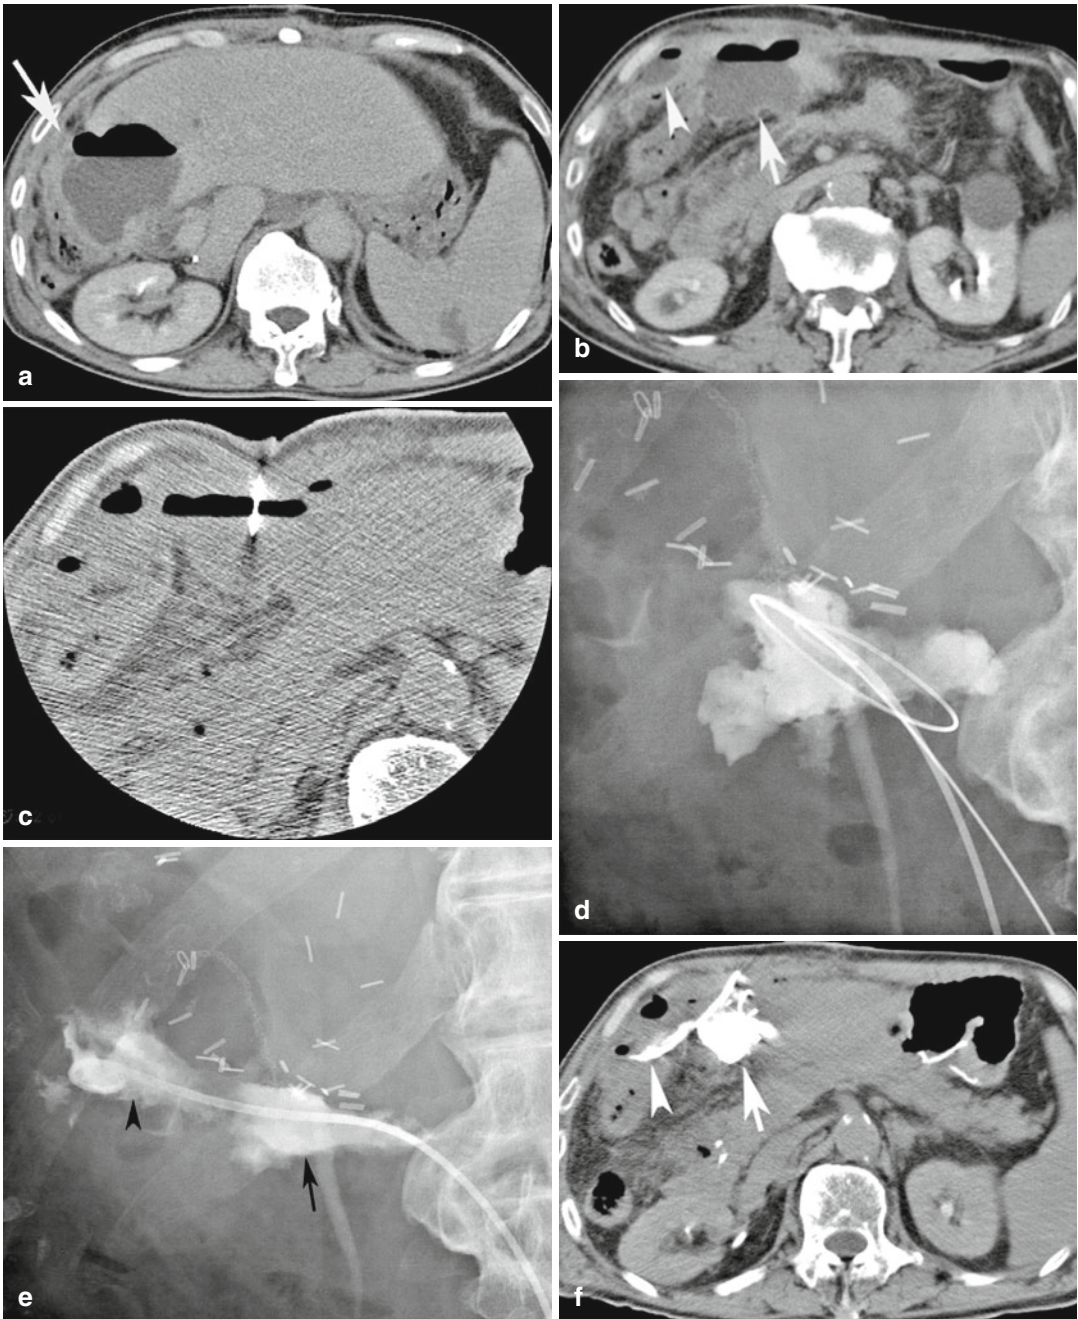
Intra-abdominal abscess after surgery. (a, b) CT before drainage shows complex abscess cavities close to the resection margin after hepatectomy (arrows and arrowhead). (c) One of the cavities was punctured under CT fluoroscopic guidance. (d) A seeking catheter and a safety guidewire were inserted into the cavity under conventional fluoroscopy. (e) A hydrophilic guidewire was introduced through the seeking catheter and successfully passed into the adjoining cavity (arrowhead), and a drainage
